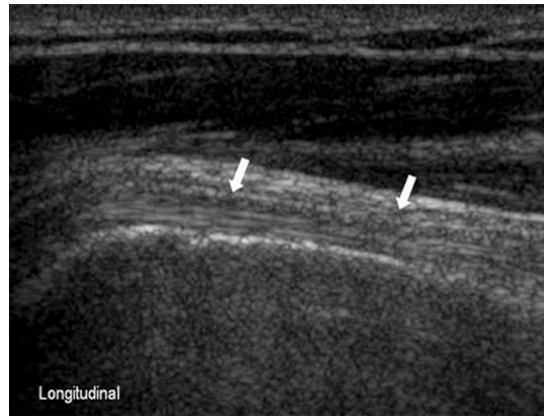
Normal biceps tendon. The ultrasound scan longitudinal to the biceps tendon shows normal, hyperechoic, parallel fibrillar pattern (arrows).*
